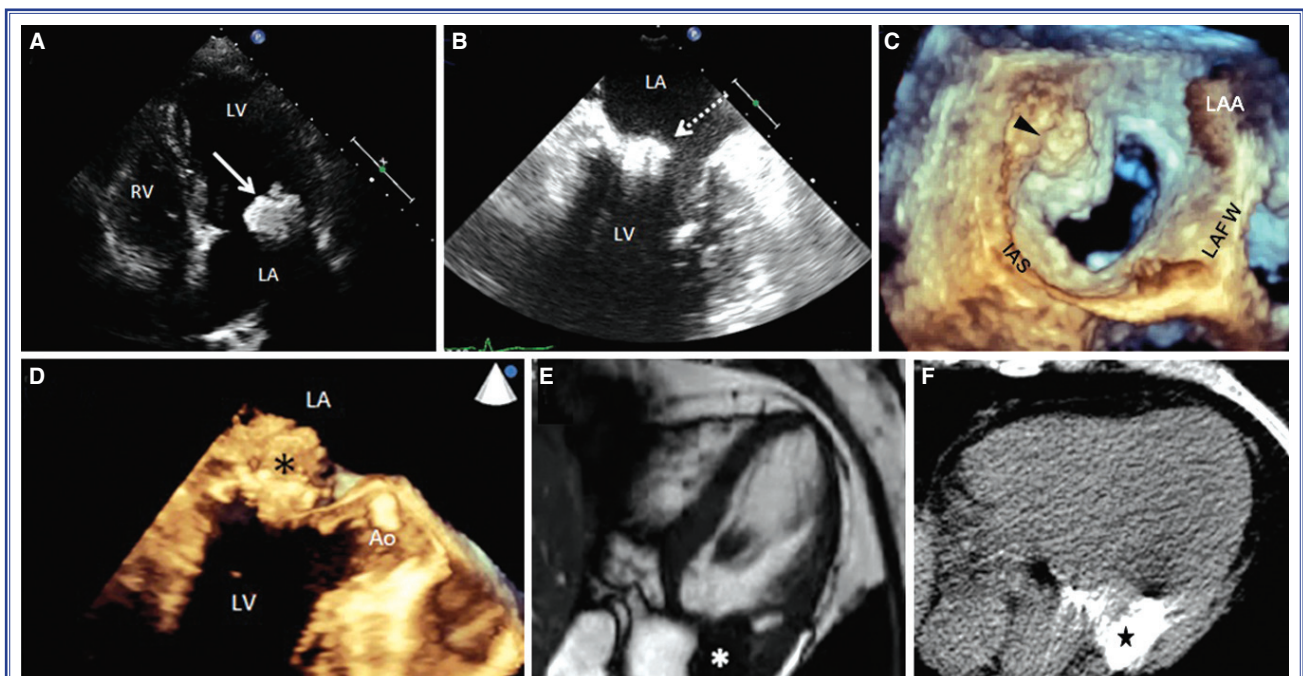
(A) Transthoracic apical 4-chamber view showing mitral annular echodense 2.9 x 3.1 cm mass (arrow) with central echolucent areas attached to the posterior leaflet restricting its motion. (B) 2D transesophageal echocardiographic image of the mitral annular mass (dotted arrow). (C) 3D transesophageal echocardiographic LA view of a heterogeneous mass (arrowhead) attached to the P2 scallop of the mitral valve annulus. Note that the leaflet was retracted by the mass. (D) Well-circumscribed mass (black asterisk) firmly attached to the basal posterior leaflet seen on 3D TEE. (E) Cardiac magnetic resonance images of the hypo-intense mass lesion (white asterisk) on both T1 and T2-weighted images. (F) Computed tomography images demonstrate a mass (star) with nodular calcifications at the base of the posterior mitral valve leaflet. There are small areas consisting of non-calcified material within the mass. LA: Left atrium; LV: Left ventricle; RV: Right ventricle; IAS: Interatrial septum; LAFW: Left atrial free wall; LAA: Left atrial appendage; Ao: Aorta.
